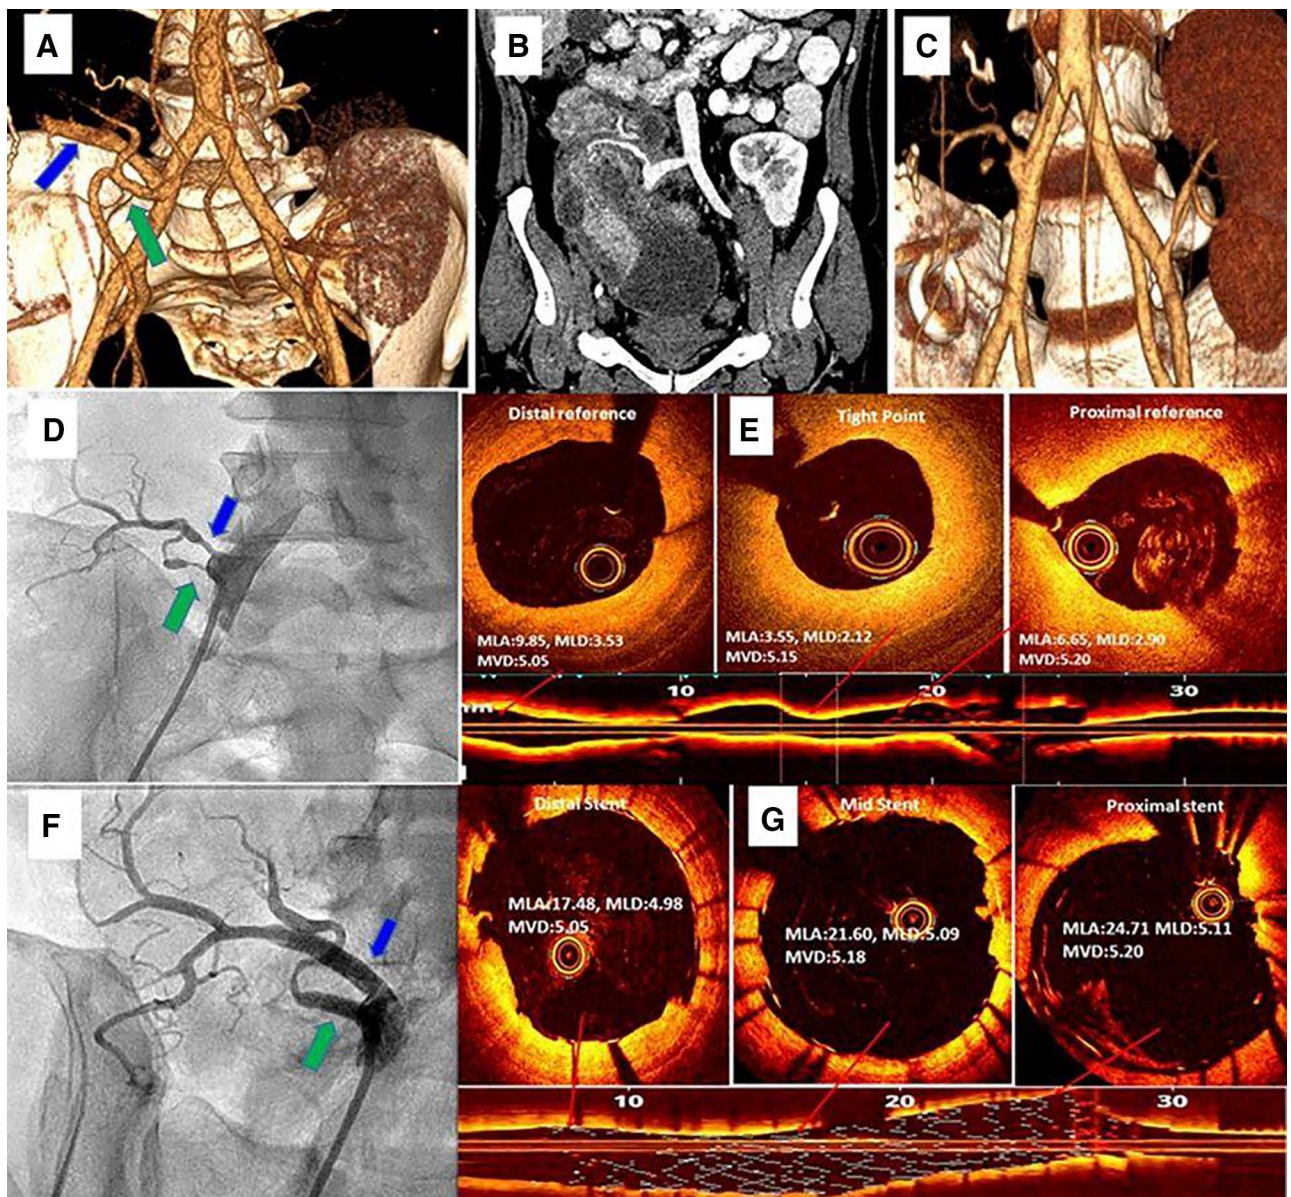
(A) 1-mo CT angiography showed patent TPA Y graft, including donor SMA (blue arrow) and donor SA (green arrow), and patent transplant renal artery. (B) 3-mo follow-up CT showed a large pancreatic pseudocyst and occluded distal SA. (C) 5-mo follow-up CT showed regression of pancreatic pseudocyst and ostial narrowing of SMA and SA. (D) Selective contrast angiogram showed ostial narrowing of SMA (blue arrow) and SA (green arrow) and total occlusion of distal SA. (E) OCT showed fibrous hyperplasia with a 60% diameter stenosis of SMA. Also depicted are the MLD in mm, MLA in mm², and MVD in mm. (F) Poststenting, a good flow was achieved in both SMA (blue arrow) and SA (green arrow), the right branch of the dorsal pancreatic artery supplying the head of the pancreas. (G) Repeat OCT of SMA showed well apposed and expanded stent. CT, computed tomography; MLA, mean luminal area; MLD, mean luminal diameter; MVD, mean vessel diameter; OCT, optical coherence tomography; SA, splenic artery; SMA, superior mesenteric artery; TPA, transplant pancreatic artery.
